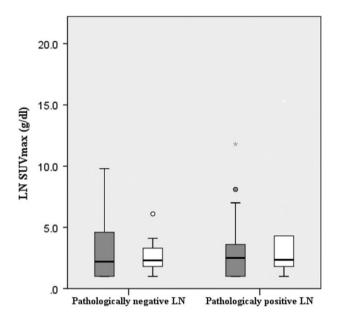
Comparison of maximum standard uptake value (SUVmax) between pathologically negative and positive regional lymph nodes (LNs). There was no significant difference in SUVmax between pathologically positive and negative regional LNs, regardless of neoadjuvant therapy. It was impossible to distinguish pathologically positive and negative regional LNs by SUVmax. , Yes.
